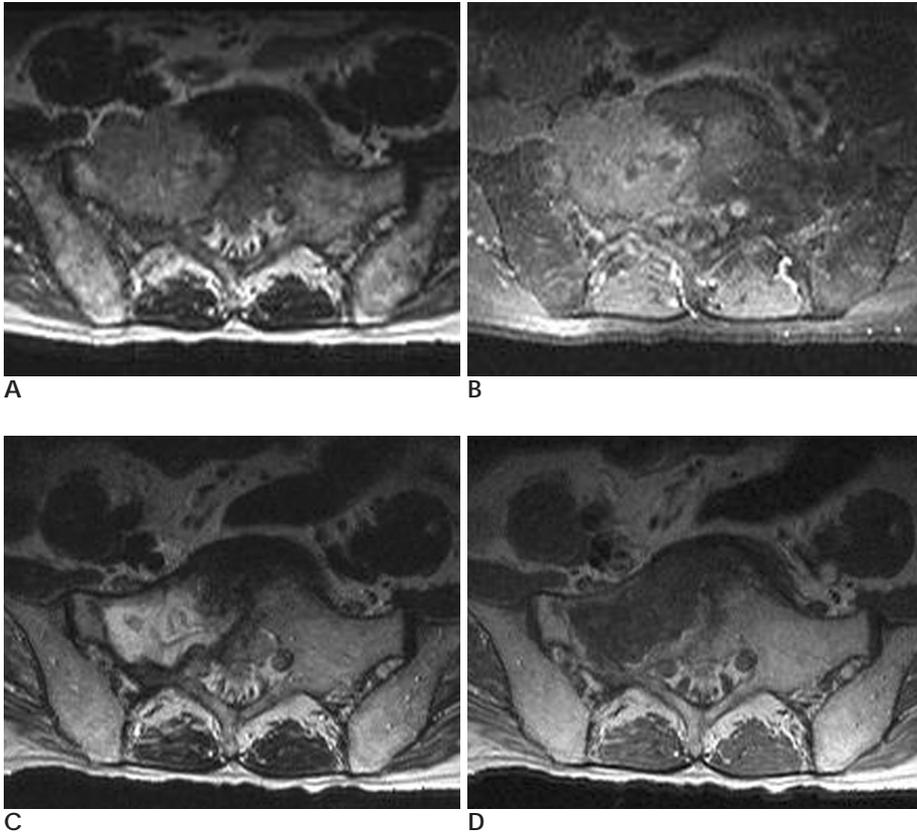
Metastatic spinal tumor in 67-year-old man with lung cancer. A, B. Metastatic lesion is noted in sacrum on axial T2-weighted (A) and contrast enhanced T1-weighted (B) images. C, D. The mass was accompanied volume loss with increased signal intensity on T2-weighted image (C) obtained on 3 months after treatment. Contrast enhanced axial T1-weighted image (D) shows extensive central tumor necrosis with mild peripheral enhancement.
